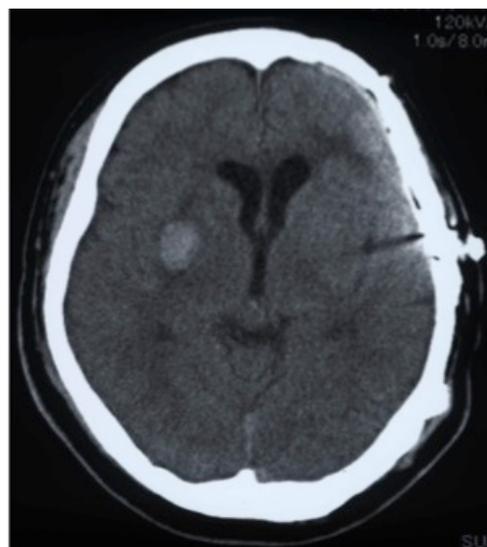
When the patient was referred to our department, an abscess on the artificial dura mater was found on CT scan.
